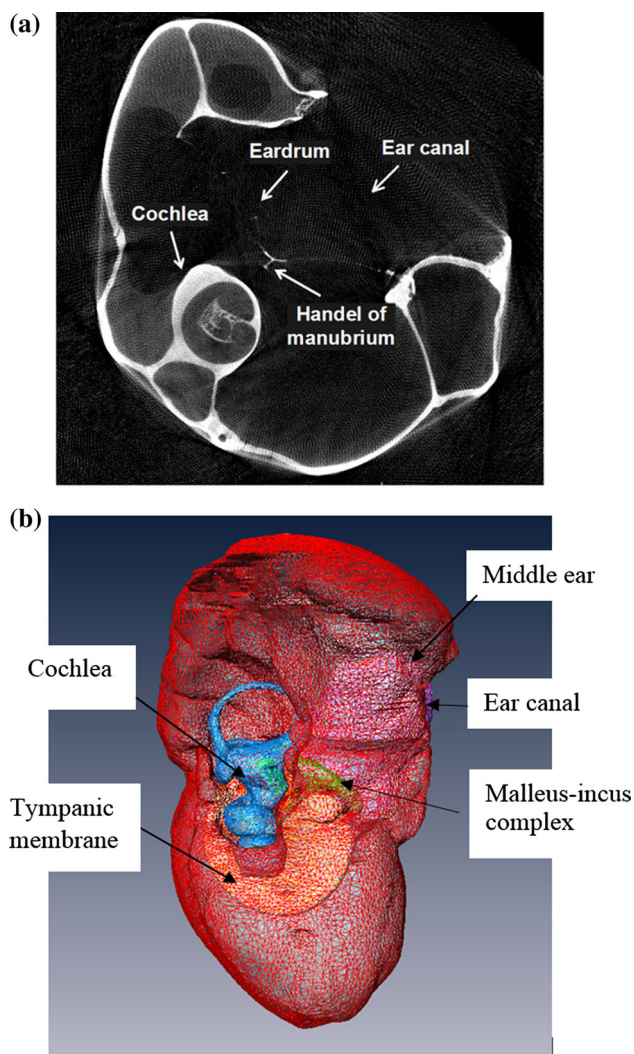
A typical μ CT image and the 3D geometrical model of a chinchilla left ear. a A μ CT image of the chinchilla bulla, showing a portion of the outer ear canal, eardrum, manubrium, middle ear cavity and cochlea. b Lateral view of the 3D model of chinchilla middle ear and cochlea reconstructed from μ CT images
